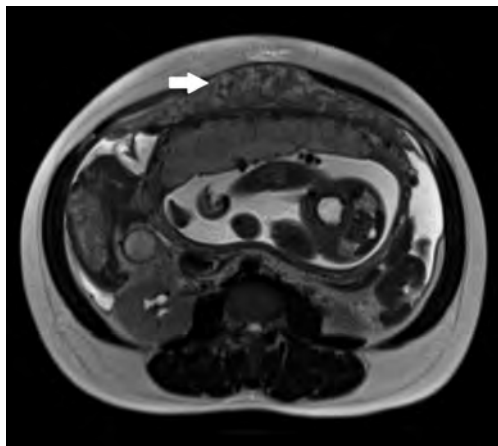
weighted magnetic resonance imaging sequence of the abdomen of a pregnant woman from Haiti. An omental mass of intermediate intensity (white arrow) is shown anterior to the uterus.
